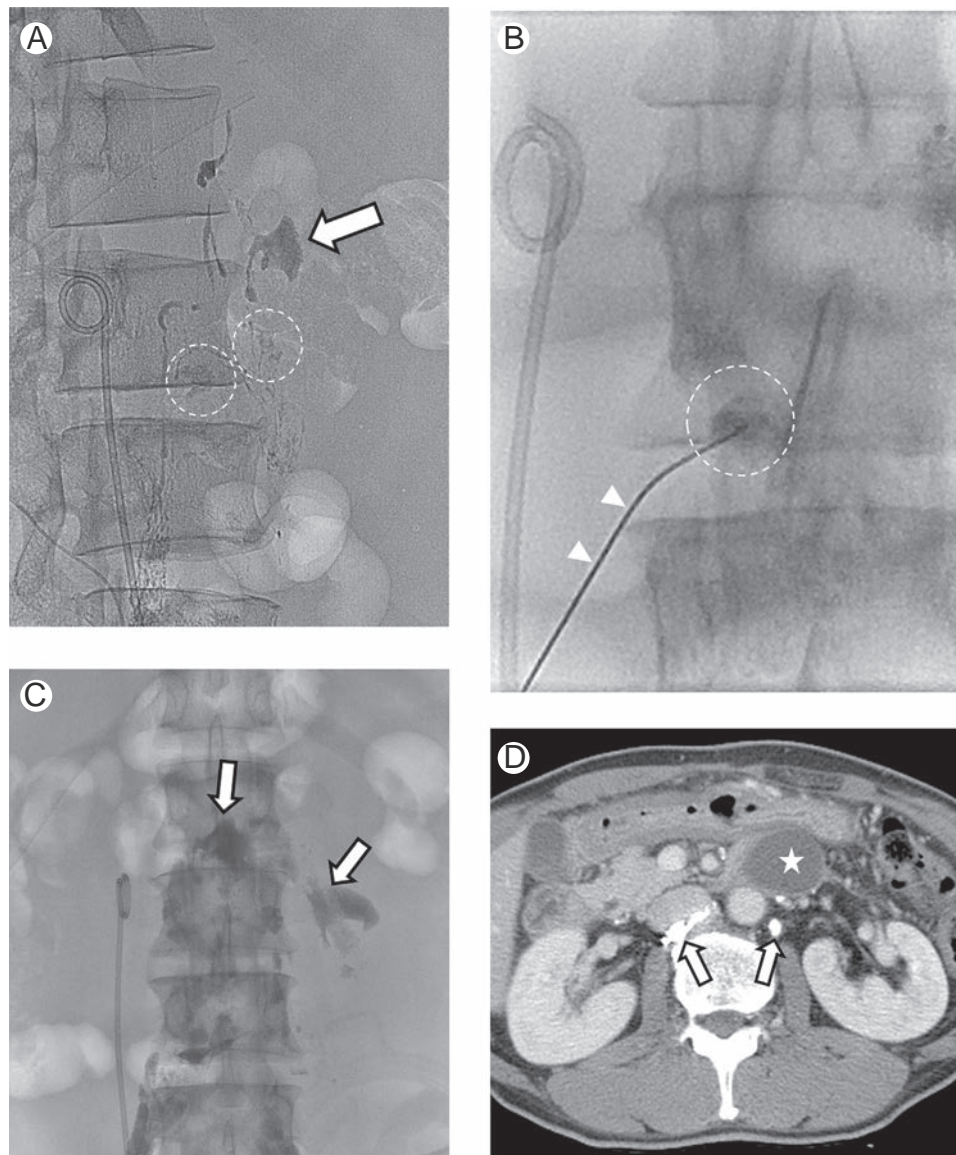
A 47-year-old male patient who developed chylothorax after surgery for rectosigmoid cancer. (A) Leakage (arrow) was identified at the site of para-aortic lymphadenectomy. White circle outlines the location of a lymph node just below the level of the leak. (B) The lymph node was targeted with a 22-gauge needle (arrowheads) which was intentionally bent just proximal to the tip for directional control within the peritoneum. NBCA and Lipiodol mixture of 1:6 was injected into the lymph node until the glue cast flowed into the leak. (C) Spot radiography taken on the following day shows the glue cast (arrows) in the retroperitoneum. (D) CT acquired seven months later demonstrated an asymptomatic lymphocele (starred) but the peritoneum was free from chylothorax. Note the remnant cast of glue (arrows) in the retroperitoneum.
